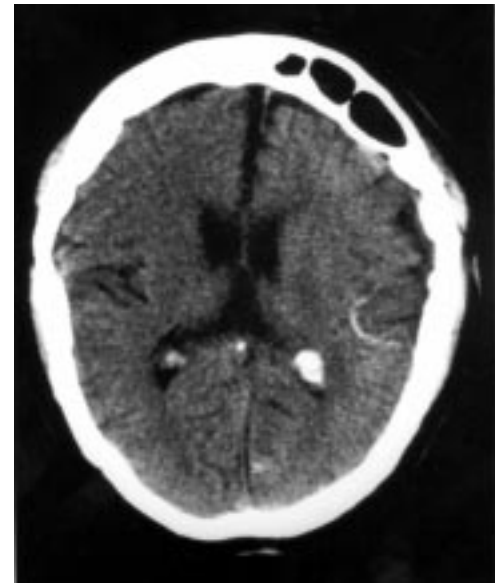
Axial contrast CT brain scan
